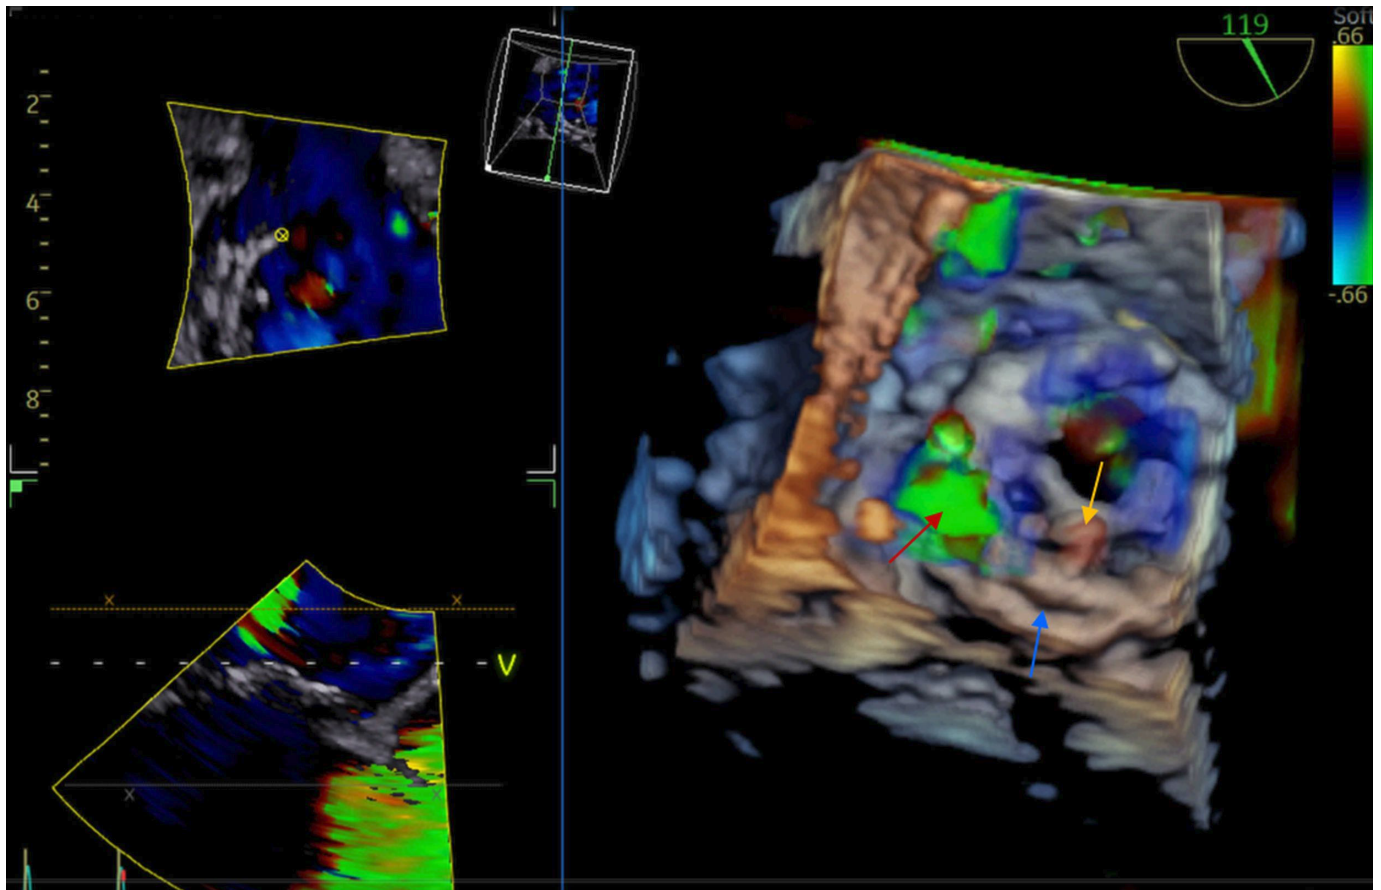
Three-dimensional transoesophageal echocardiography prosthetic mitral valve endocarditis enface view vegetation on the ring (orange arrow), annular dehiscence (blue arrow) and paraprosthetic leak (red arrow).
